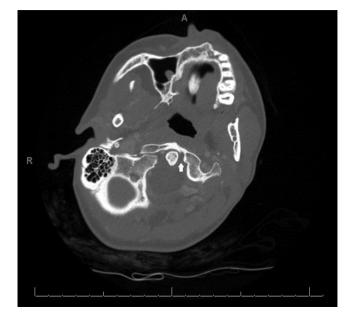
Axial view of the CT of cervical spine shows rotation of the atlas (C1) on a fixed axis (C2) with decreased distance between the odontoid (C2) and lateral mass of the atlas (C1) indicating atlantoaxial rotatory subluxation (arrow).
